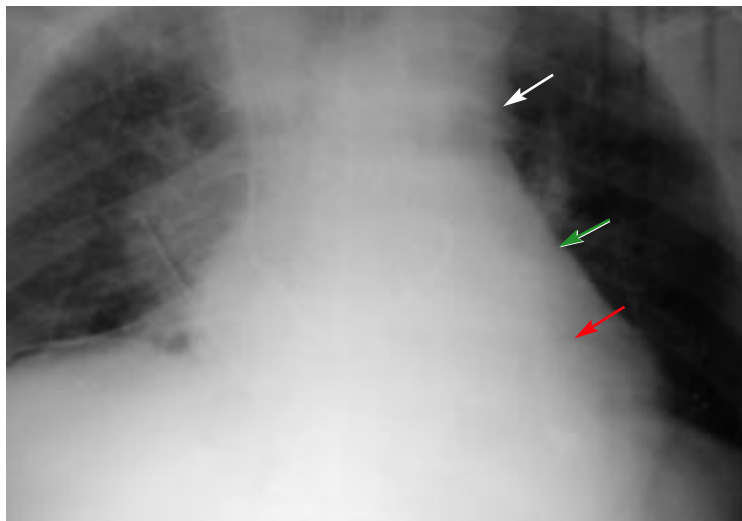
Chest radiography reveals significant superior mediastinal widening (white arrow), cardiomegaly (red arrow), and pericardial effusion (green arrow).
